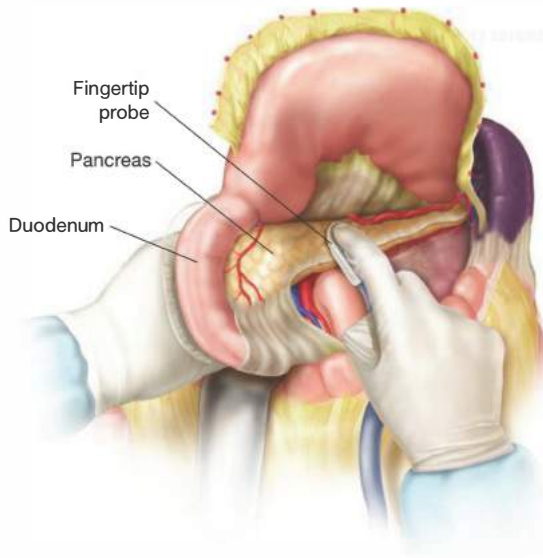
• Ultrasound examination of the duodenum and pancreas.
